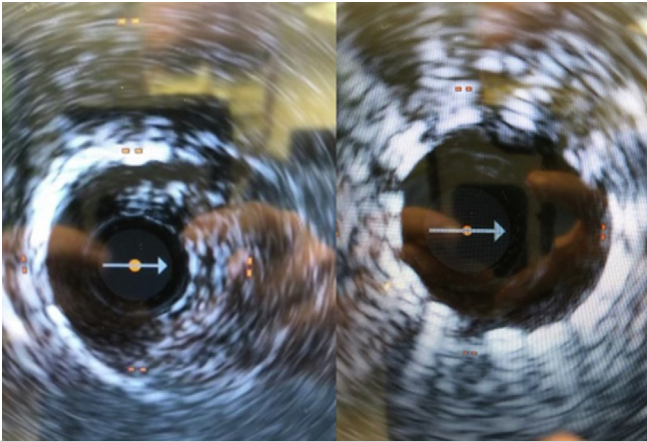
Intravascular ultrasound (IVUS) evaluation before and after Tack deployment in treatment of dissection.
